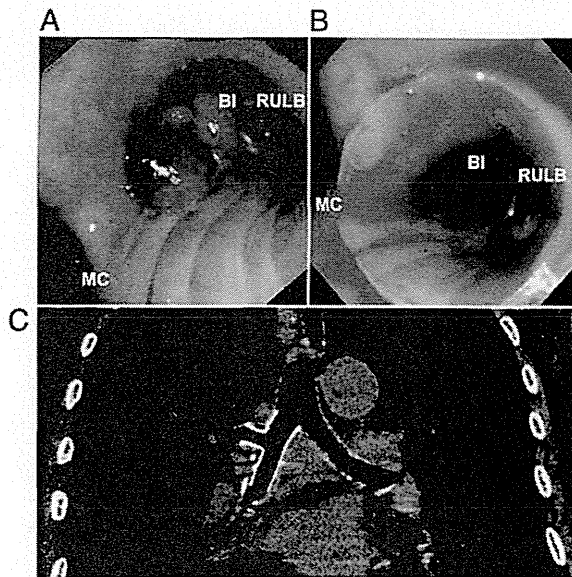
Bronchoscopic views and CT image of patient 1 in Tables 1 and 2. A, Bronchoscopic view before stent placement, showing the right main stem bronchus and the BI invaded by colon cancer. B, Bronchoscopic view after stent placement on the primary right carina. C, CT image after stent placement on the primary right carina. BI = bronchus intermedius; MC = main carina; RULB = right upper lobe bronchus.
